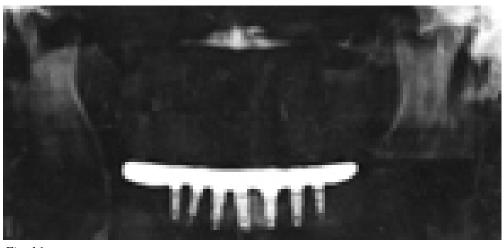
Post-op panoramic radiograph
